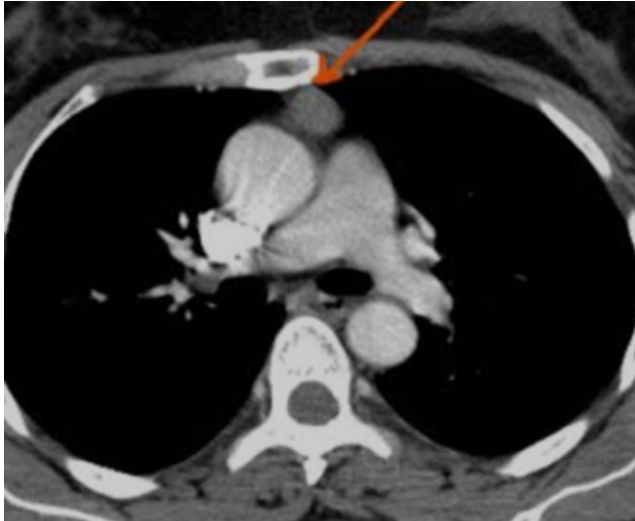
Thoracic CT showing anterior mediastinal mass.
